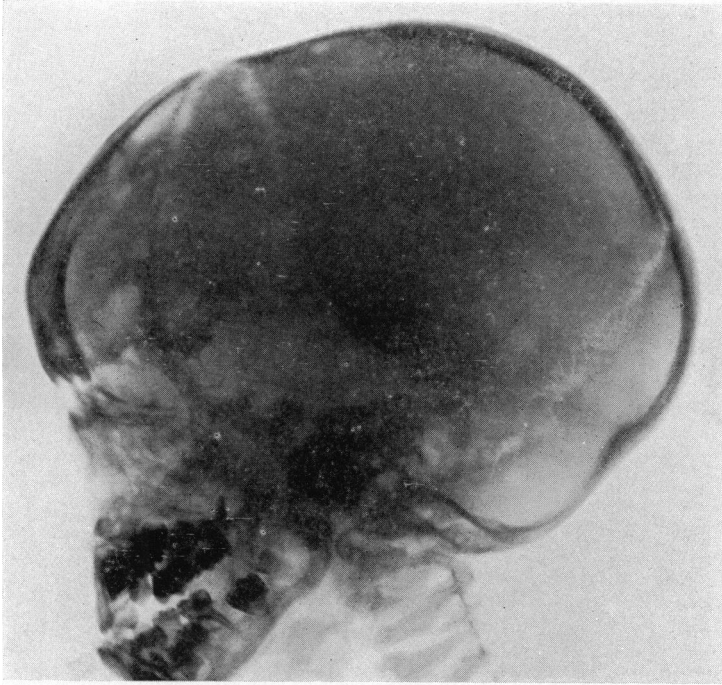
X-ray of skull, showing large defects due to loss of bone, especially wholesale destruction of bone in orbital region.
